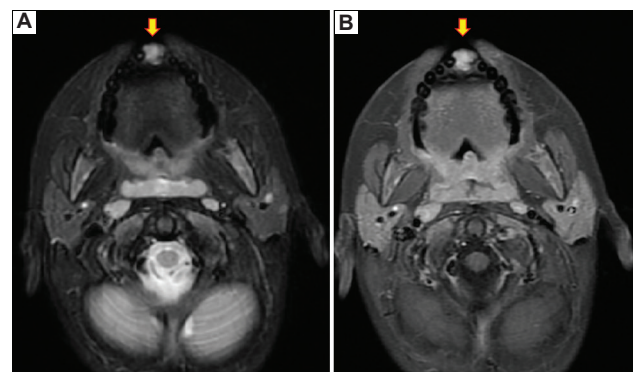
Magnetic resonance imaging images. (A) T2-weighted STIR imaging showed a high signal intensity (arrow). (B) Gadolinium contrast T1-weighted imaging showed a well-defined mass, measuring 13 × 10 mm, with a contrast effect (indicated by arrow).
